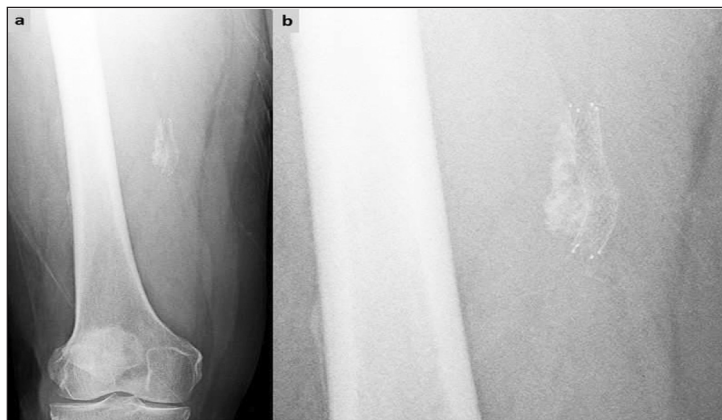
Anteroposterior radiography of the femur (a) and magnification of the lesion area (b). Due to the close relationship with the calcific lesion, the superficial femoral artery stent indentation was observed.
